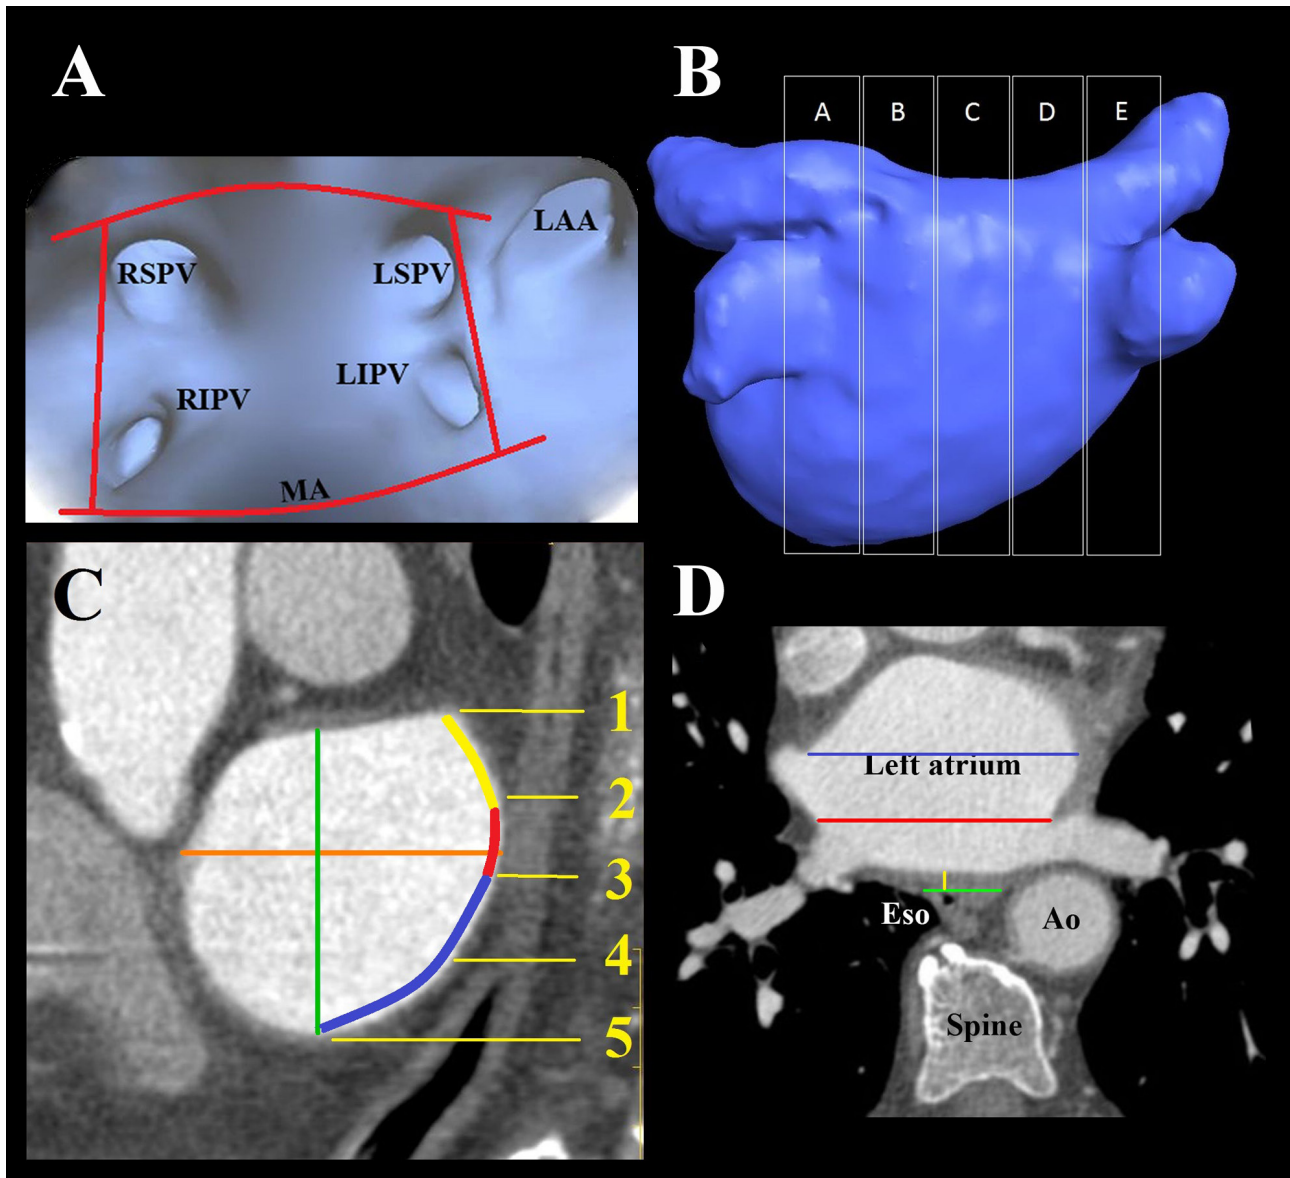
(A) CT image from endovascular anteroposterior projection. Posterior wall of the LA was defined (red lines) by a superior line formed by the most superior points of the roof of the LA. The medial line tangential to the most medial (right-sided) points of the ostia of the right-sided PVs, a lateral line that was tangential to the most medial (left-sided) points of the ostia of the left-sided PVs, and an inferior line formed by the posterior mitral annulus or the most inferior points of the bottom of the LA, (B) Methodology of assessment of esophageal position, posteroanterior view, (C) Measurement in sagittal plane, the different levels in which the widths of the esophagus and the distance esophagus - LA were measured in the transverse plane, yellow lines 1-5, measurement of the depth of the LA (anteroposterior diameter), orange line, measurement of the height of the LA (superoinferior diameter), green line, measurement of the contact of the esophagus and LA, area of close contact is highlighted in red, superior segment of fat pad in yellow color, inferior segment in blue, (D) Measurement in the transversal plane, width of the LA (transverse diameter) blue line, width of the posterior wall of the LA, red line, width of the esophagus, green line, measurement of the distance of the esophagus and LA, yellow line. LSPV - left superior pulmonary vein, LIPV - left inferior pulmonary vein, RSPV - right superior pulmonary vein, RIPV - right inferior pulmonary vein, LAA - LA appendage, MA - mitral annulus.
